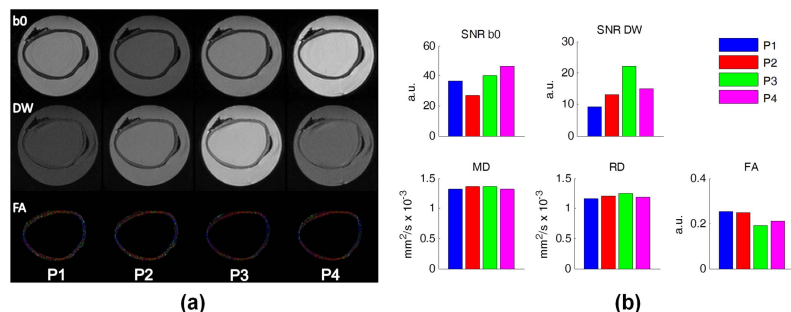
a) Mid-slice images acquired using four DTI scan protocols: b0-image (upper row), average of the DWI images (middle row) and color-coded FA map (bottom row). b) Quantitative analysis of the different DTI protocols in terms of SNR and diffusion indices.
